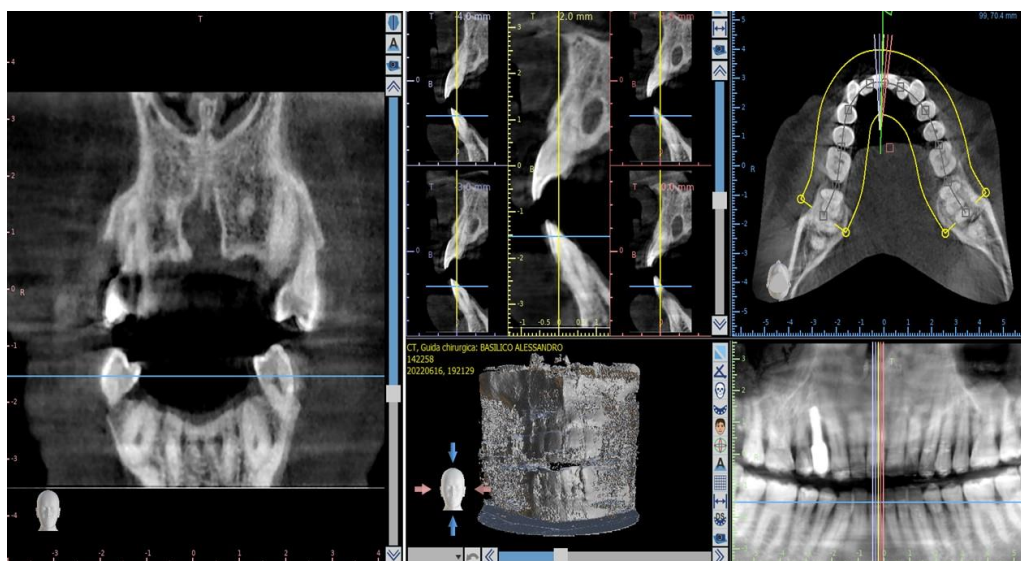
A well-defined, unilocular radiolucent lesion in the maxillary anterior region on the CBCT was detected.
